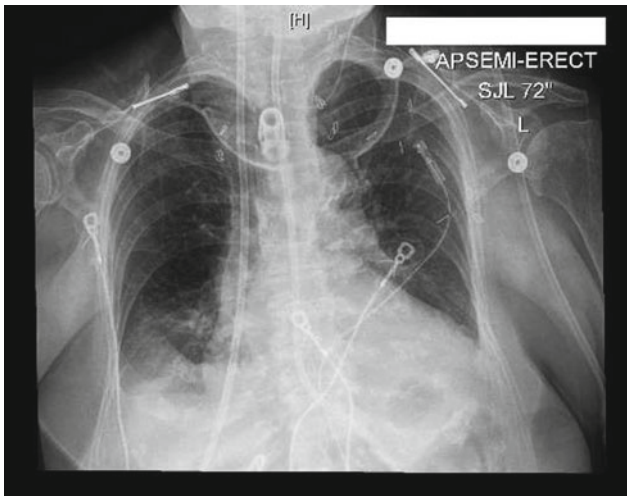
Postoperative chest X-ray. Bibasilar opacities are evident, indicating atelectasis and/or pneumonia
